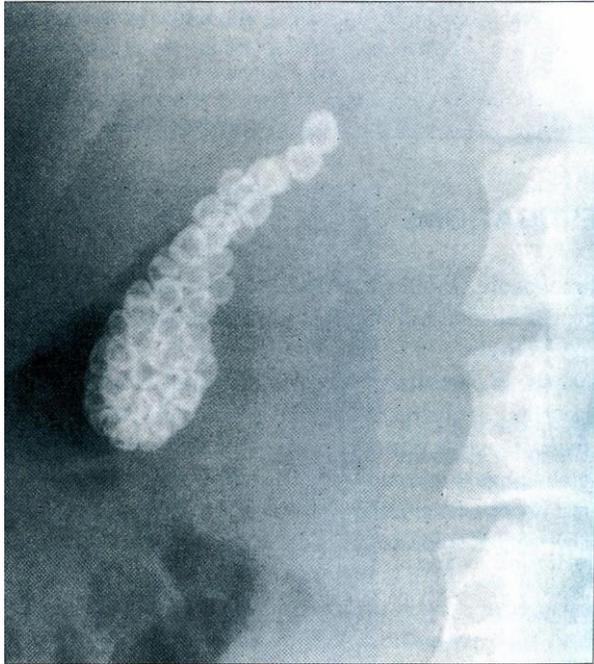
Calcified gallstones seen on plain X-ray. Only about 10% of gallstones contain enough calcium to be visible on the plain film. This patient had had remarkably few symptoms before the incidental discovery of her gallstones.
